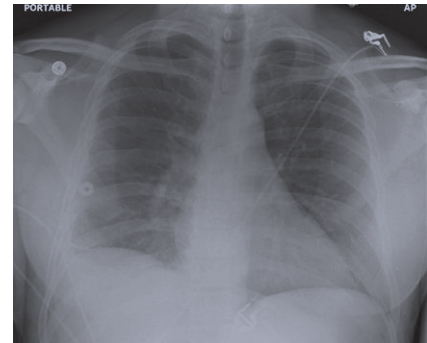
A follow-up chest radiograph indicates that the pleural effusion has resolved.
